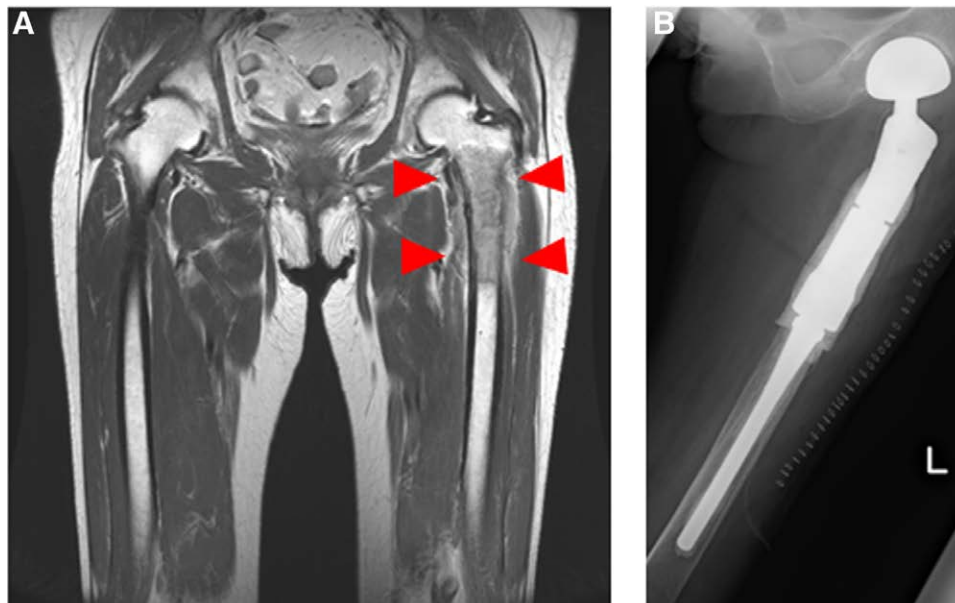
(a) MRI image of a patient's left-sided tumor. The red arrow heads show the tumor. (b) X-ray image after MP reconstruction. The cement line is observed around the implant.
